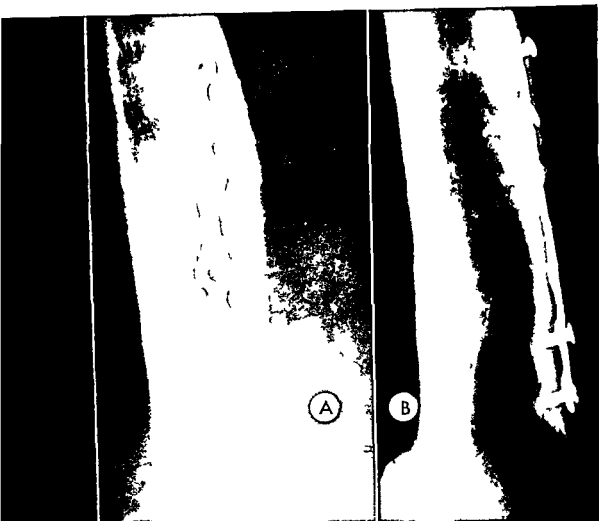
(A and B) Antero posterior and lateral radiographs of vanadium steel plate and screws inserted some 20 years previously to treat a fractured femoral shaft. The fracture united and all went well until the leg suddenly became tender and swollen. Gross corrosion of the implant is visible with almost complete disintegration of the screws. The plate is practically corroded through at its center. A marked periostitis is seen in the complete absence of infection.
